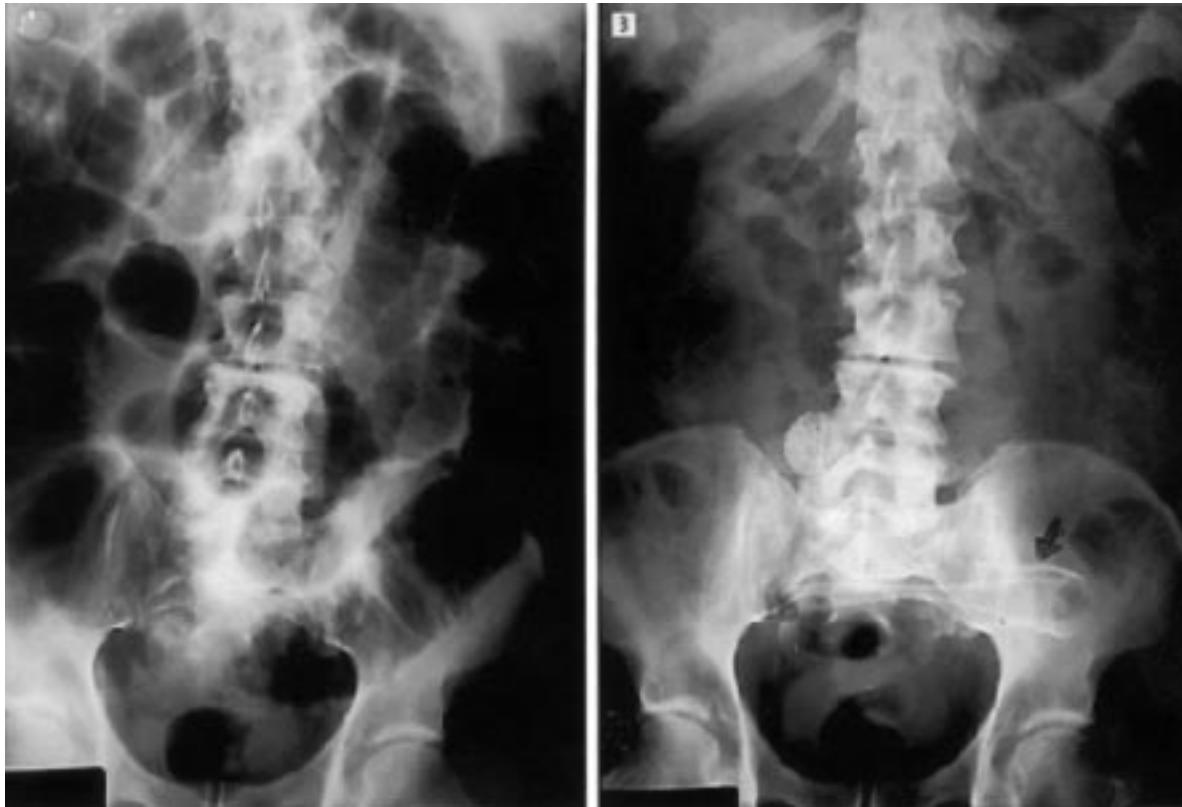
Plain abdominal X-ray; A- Before insertion of the stent showing multiple fluid levels, B- After insertion of the stent showing relief of colonic obstruction.
